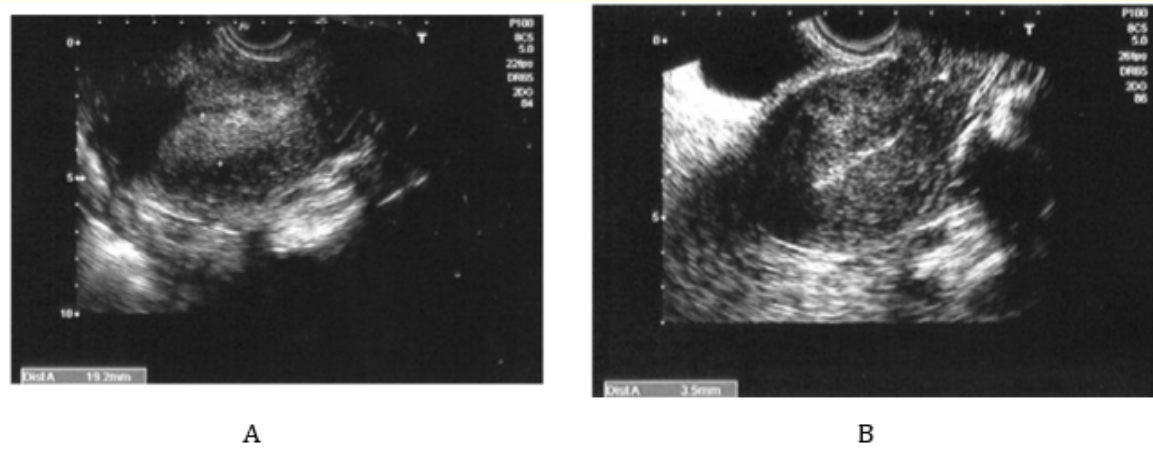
(A) Showing thickened endometrium (endometrial thickness=19.2 mm) on transvaginal sonography in a woman with post-menopausal bleeding and (B) Thin endometrium (endometrial thickness=3.5 mm) on transvaginal sonography in a woman with post-menopausal bleeding [8].
